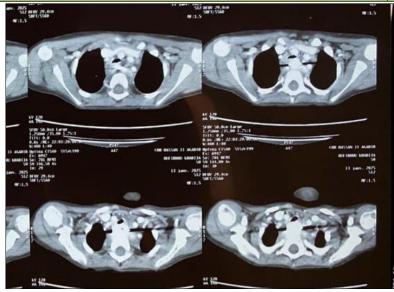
Cervicothoracic CT scan confirming the presence of a metallic-density foreign body in the thoracic esophagus, with esophageal wall thickening and posterior mediastinal fat infiltration
